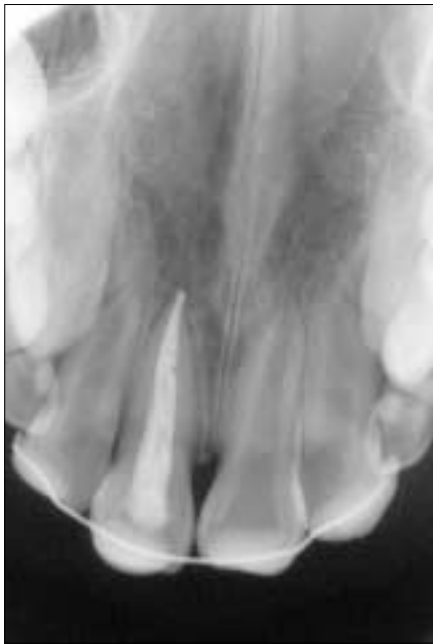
Maxillary occlusal radiograph taken immediately after replantation shows proper repositioning of avulsed tooth 11.
